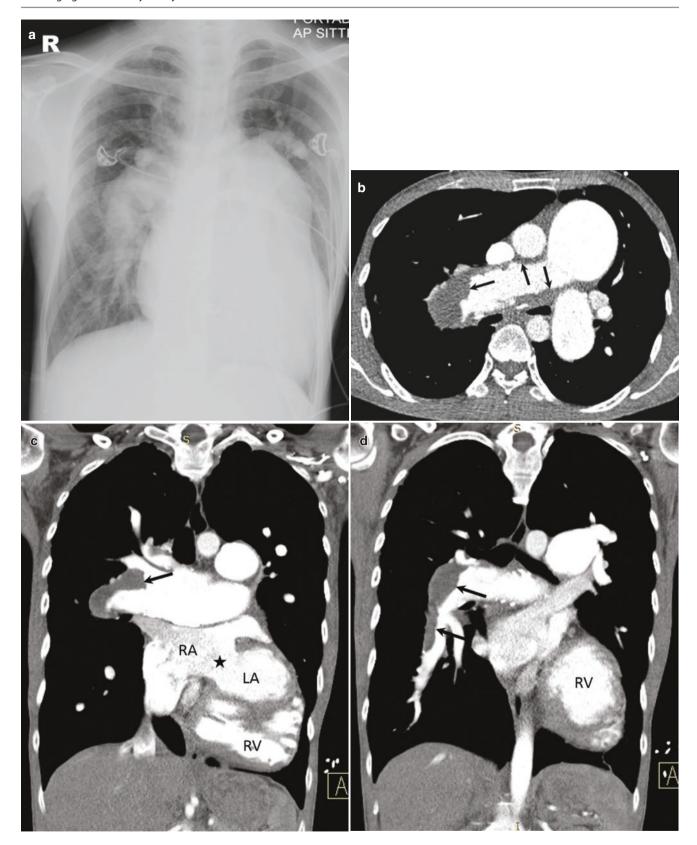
Pulmonary artery thrombosis in a 46-year-old man with undiagnosed atrial septal defect (ASD), PAH, and Eisenmenger syndrome. (a) Chest radiograph shows markedly dilated pulmonary arteries and cardiomegaly. (b–d) Axial and coronal CTPA images
